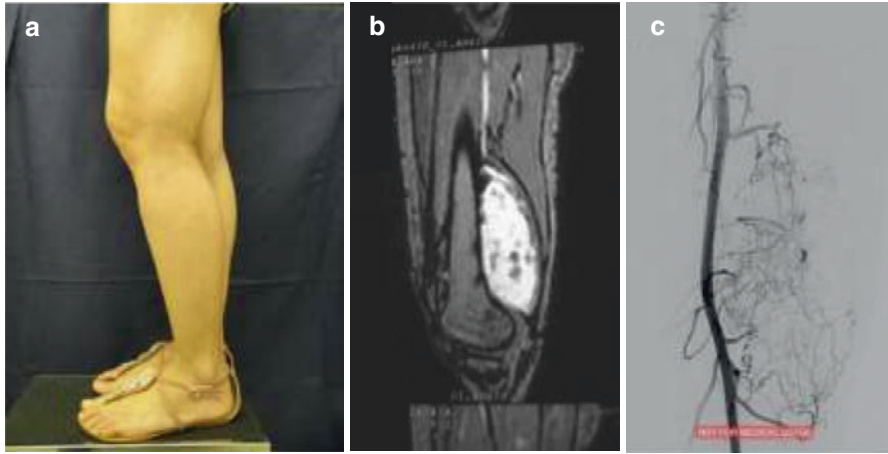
(a) A.A.T. Female, 27 years old. Non-pulsatile tumor on lateral and posterior sides of left thigh beginning in adolescence. (b) MRI of left thigh: coarsely oval image of lobulated margins with intima counted with the biceps femoral muscle presenting intermediate signal at T1 and high signal intensity in the STIR sequence with intense impregnation and homogeneity by the paramagnetic agent. (c) Left femoral arteriography: several arterial pedicles from the superficial femoral artery irrigating with high-flow the vascular malformation associated with multiple smaller size arterial branches (arterio-arterial anastomosis) as a consequence of previous embolizations
